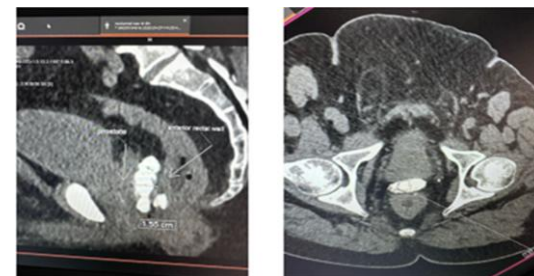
Sagittal & axial CT — spacer separating prostate from rectal wall
